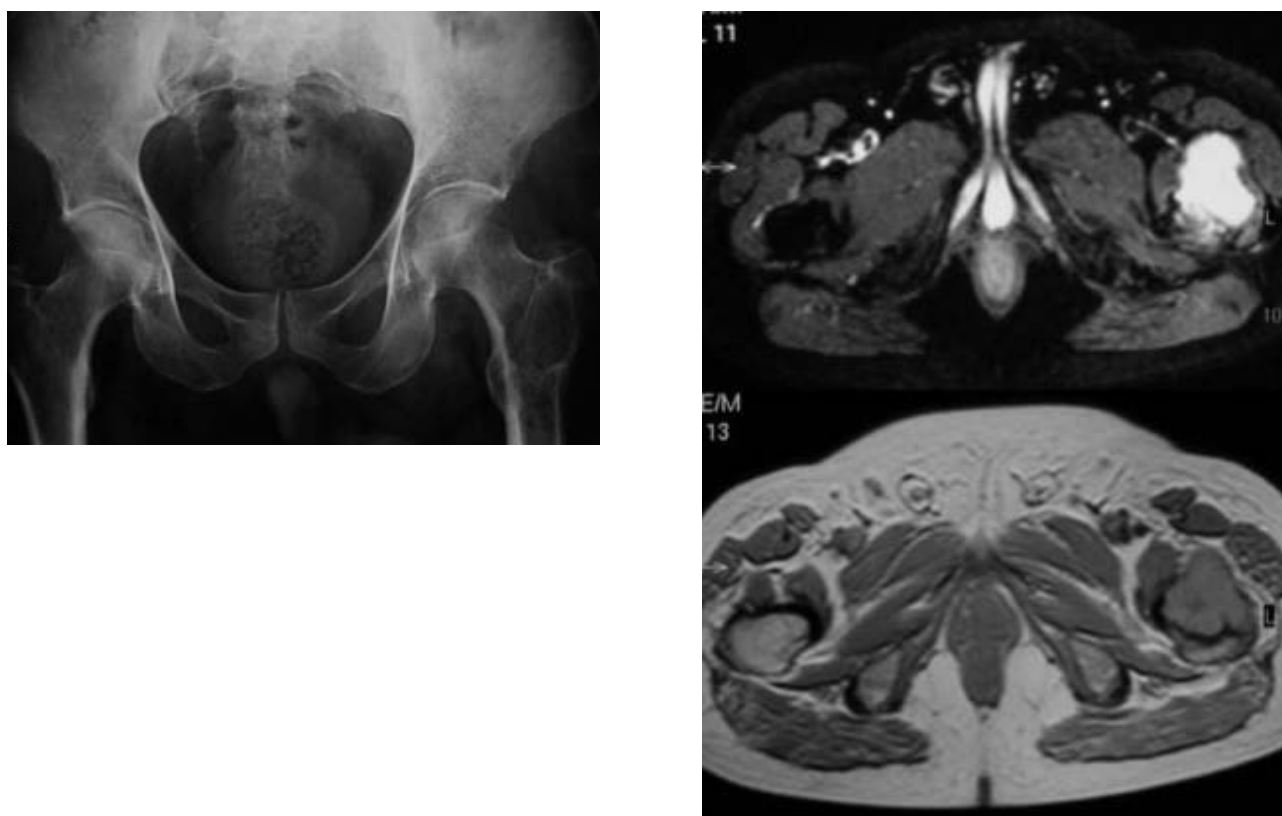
X-rays and MRI shows proximal femur metastases from renal cell carcinoma.
